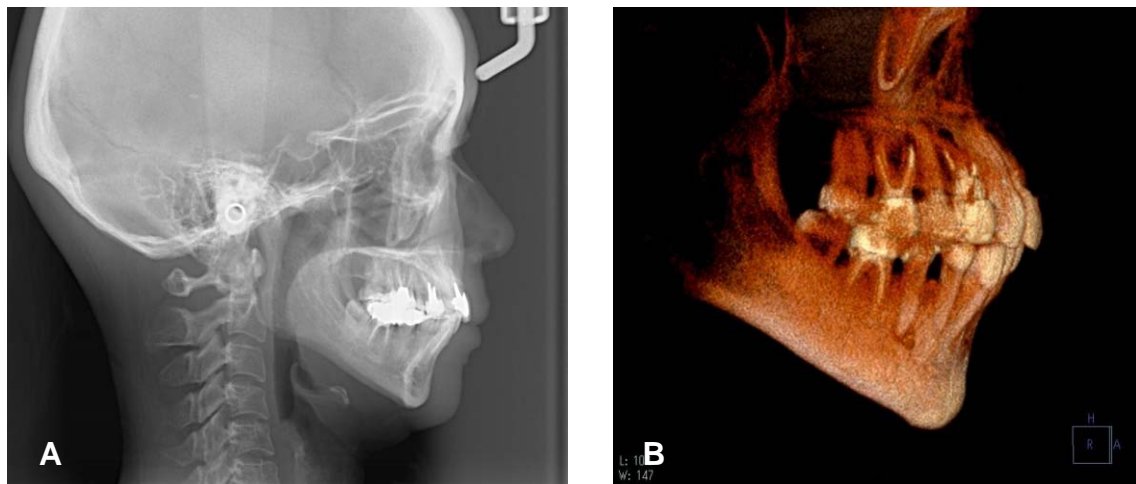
Radiographic views after six-year of postretention (6 years posttreatment): A, Lateral cephalometric view. B, The volume-rendering 3-dimensional computed tomography.
